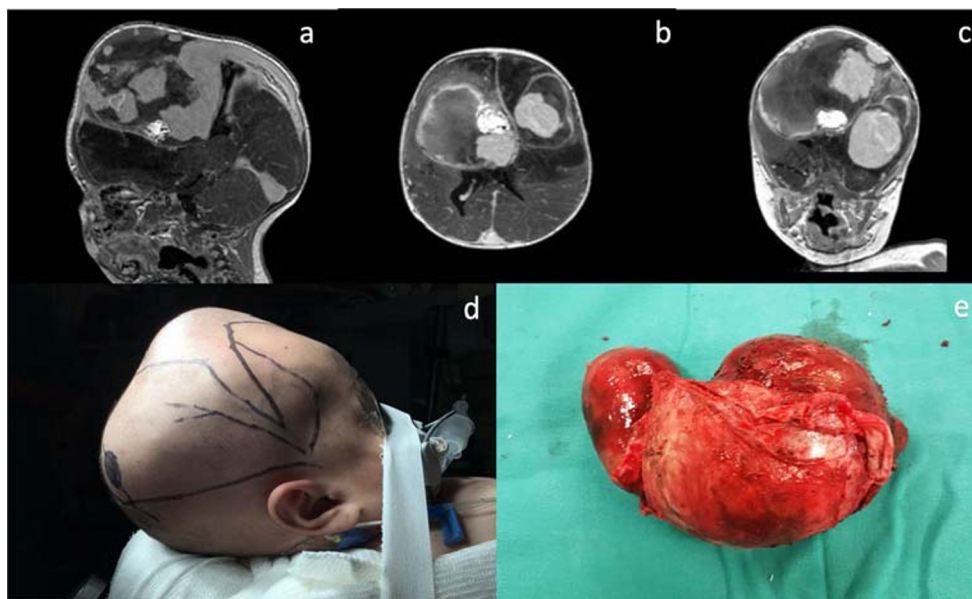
Magnetic resonance imaging (MRI) of the brain. a Sagittal view of the brain MRI after the first embolization, partially thrombosed venous sacs and hemorrhage can be seen at different stages. Flow is observed in the posterior two-thirds of the superior sagittal sinus. b Axial view of the brain MRI showing the lesion with different heterogeneous areas of thrombosis and hemorrhage. Also, we can see the embolization material.
